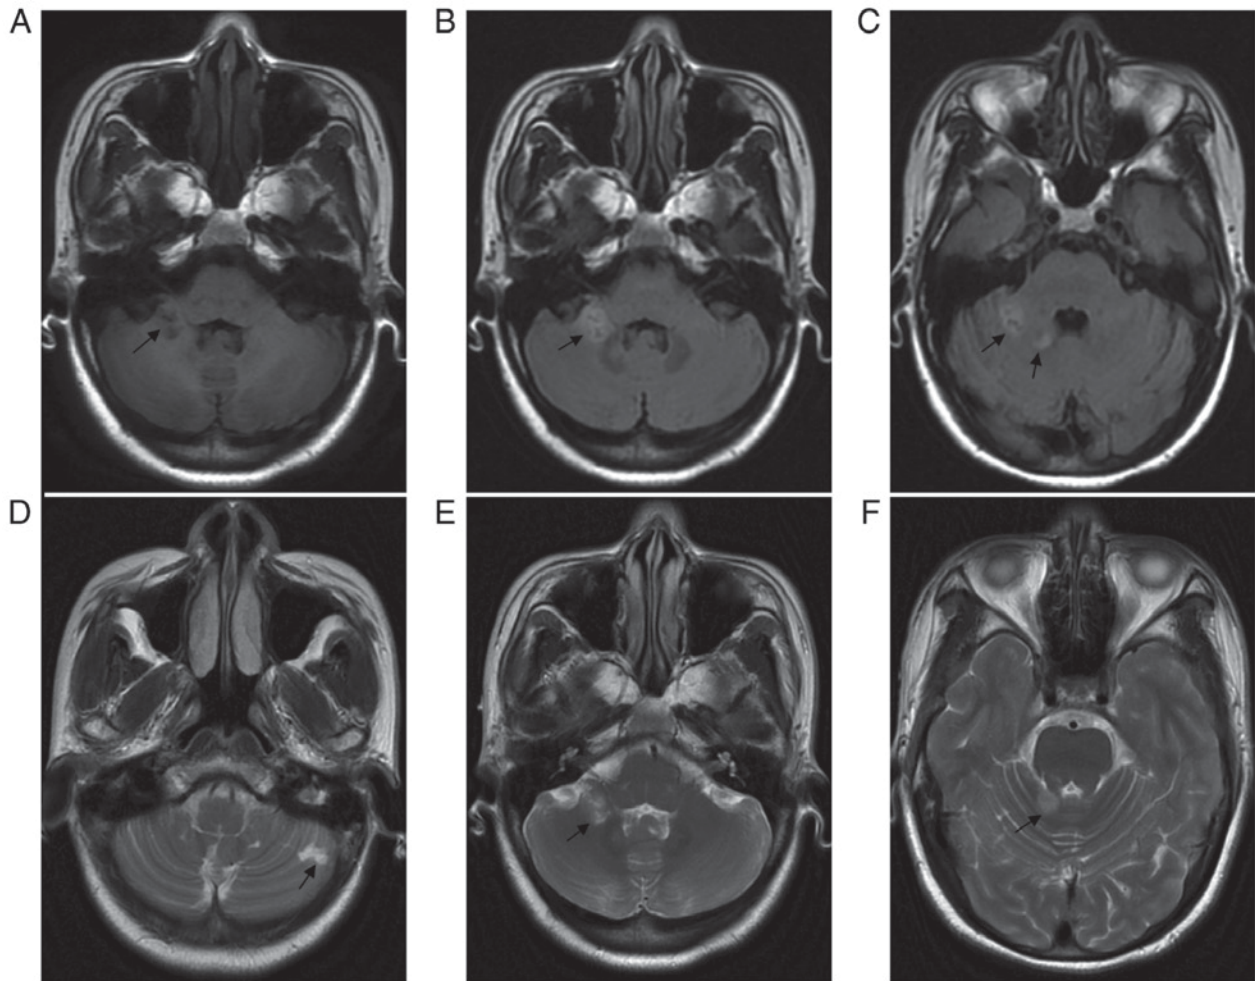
Magnetic resonance imaging of the brain indicated acute ischemic stroke in the right cerebellar hemisphere and cerebellar vermis, and a previous cerebral infarction in the left cerebellar hemisphere. (A) T1 weighted image revealed a low signal in the right cerebellar hemisphere. (B and C) T1 Flair weighted image showed multiple high signals in the right cerebellar hemisphere. (D) T2 weighted image revealed a high signal in the left cerebellar hemisphere. (E and F) T2 weighted image revealed several different high signals in the right cerebellar hemisphere.
